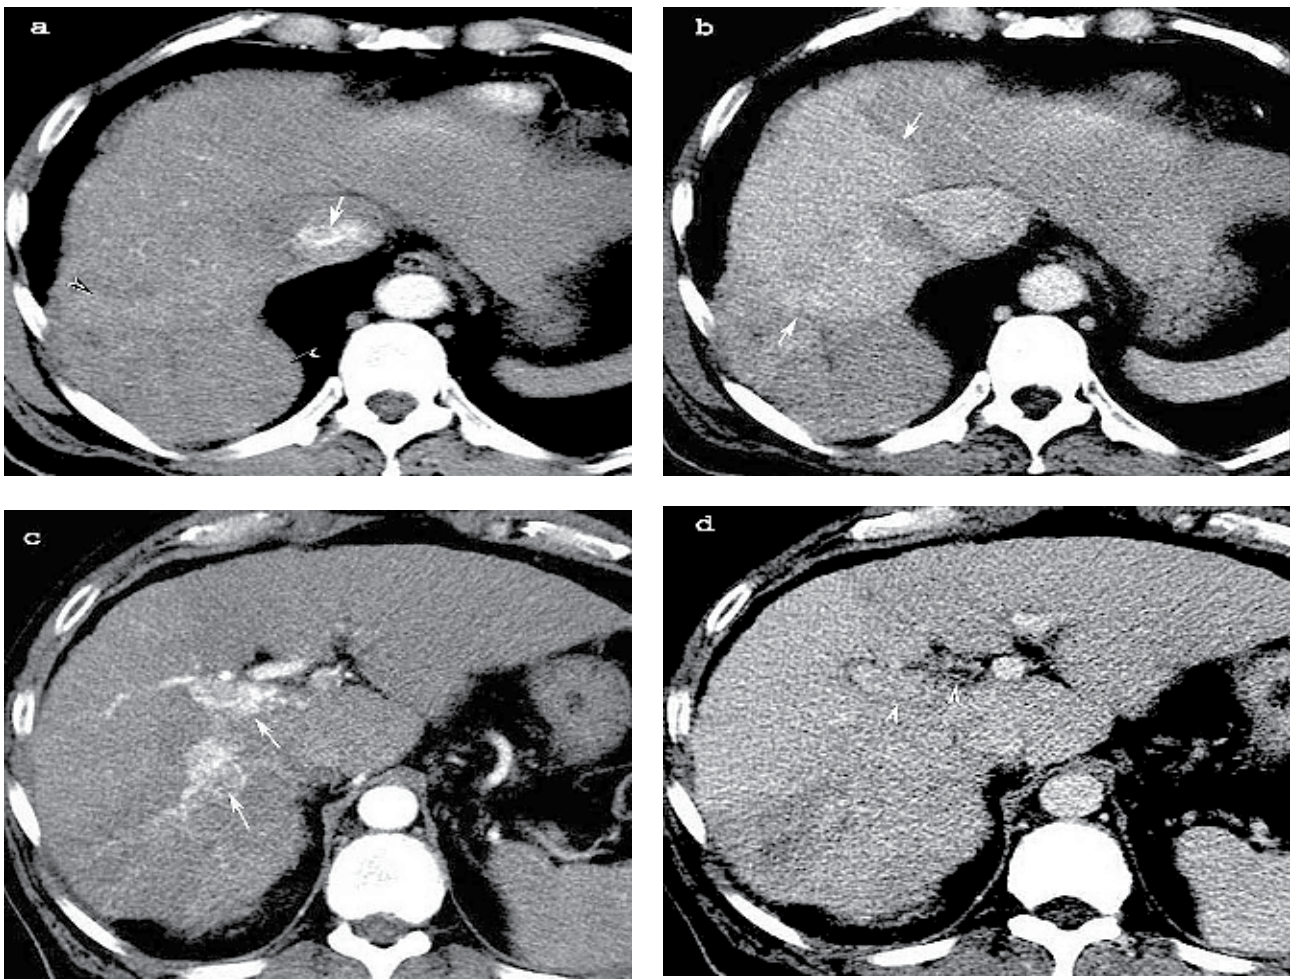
Right hepatocarcinoma, arterio-hepatic shunts (long white arrows) and right portal venous thrombosis with extension of the thrombus into the portal trunk (white arrow head). a, c - arterial and b, d - portal spiral CT phase.
